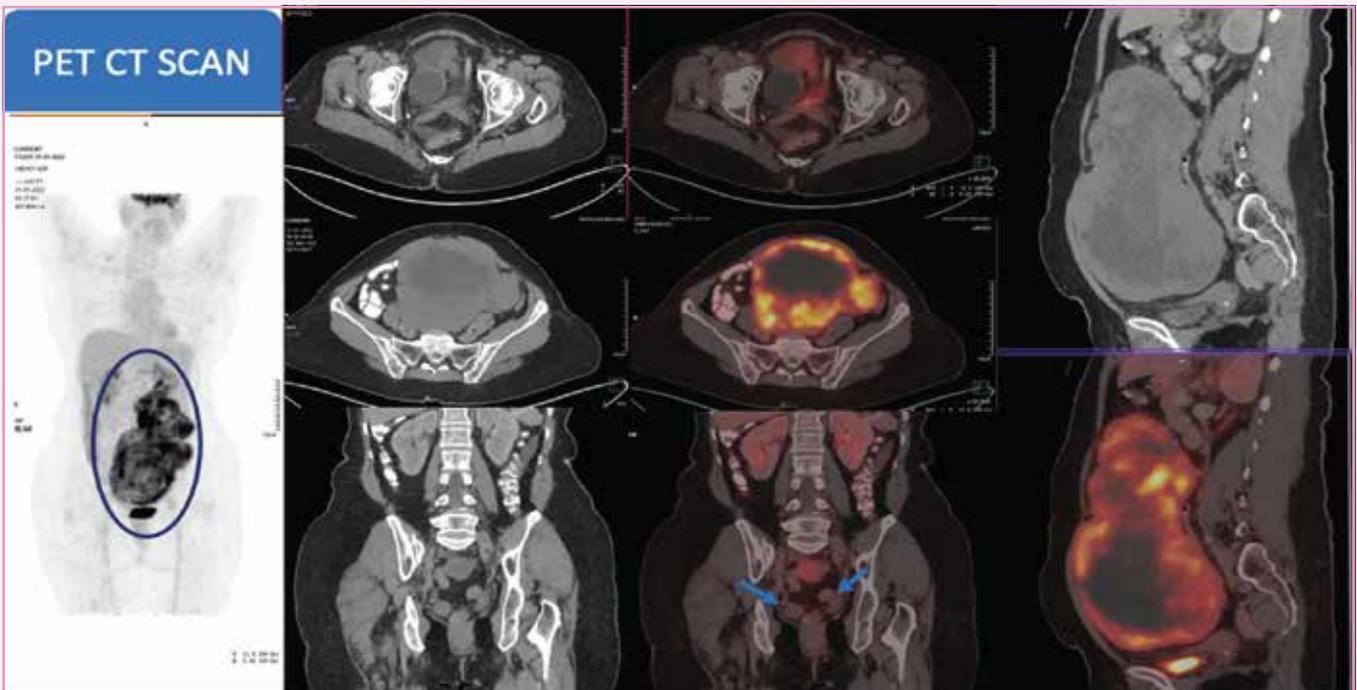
PET CT—Large FDG avid soft tissue mass ~14.9x16x23.7cm with large areas of necrosis and few specks of calcification in left side of pelvis. Bilateral ovaries not visualised separately. Mild ascites.
